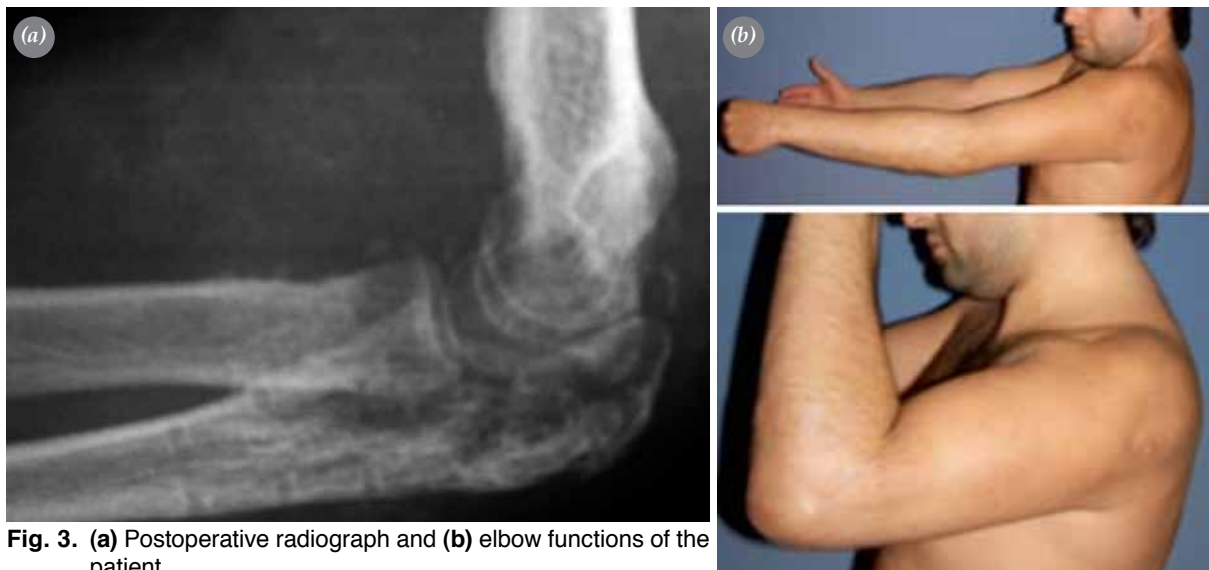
(a) Postoperative radiograph and (b) elbow functions of the patient.
